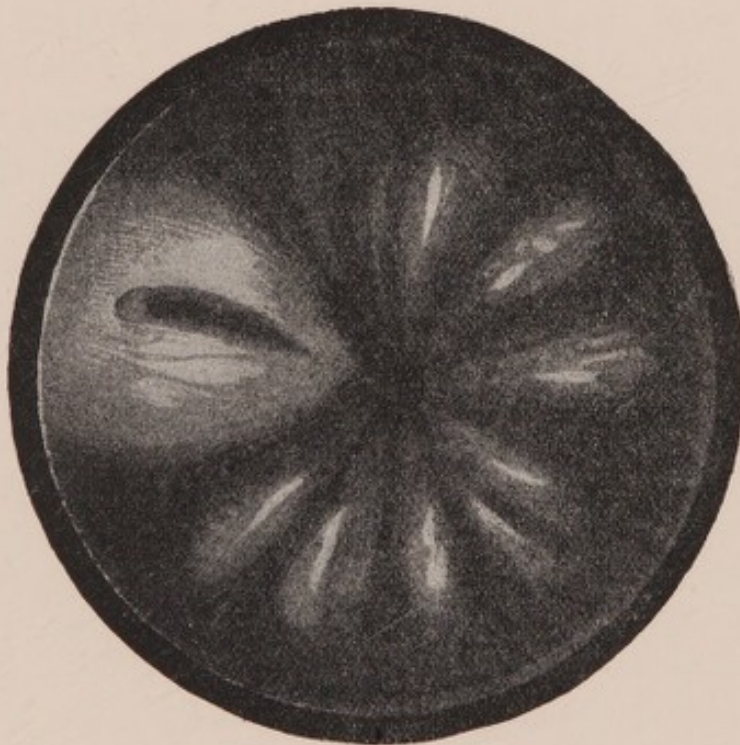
ASPECT OF THE URETHRA AFTER IT HAD BEEN CURED BY MEANS OF INTERSTITIAL ELECTROLYSIS.
